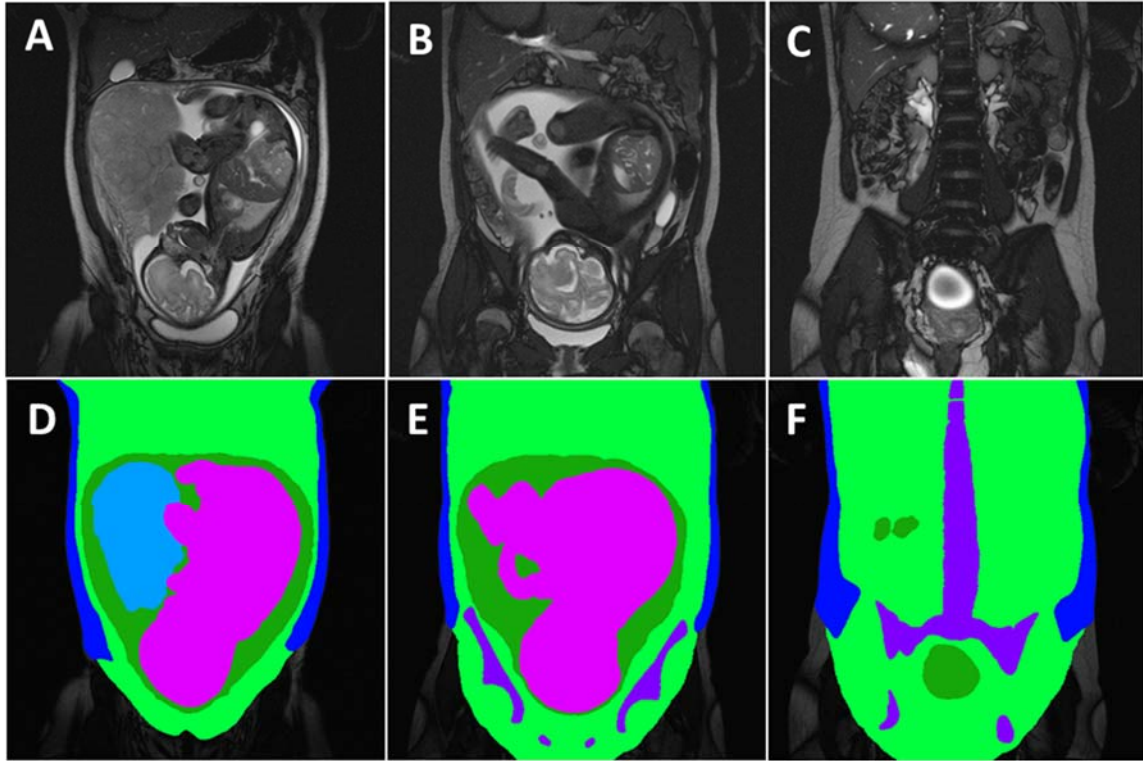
Tracing of MRI Scans for ScanIP
